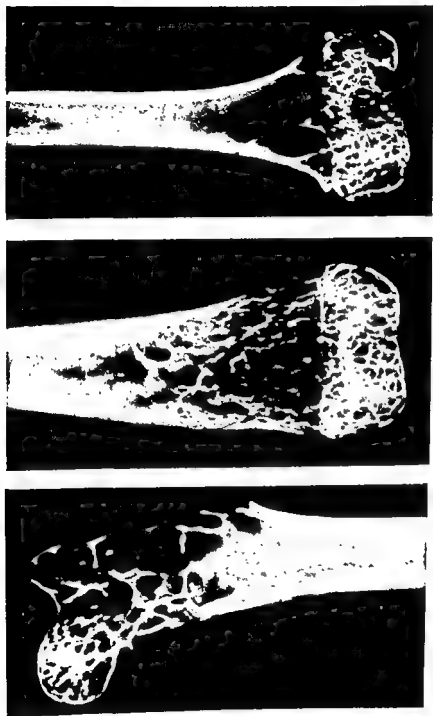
Frontal radiographs of proximal end of femur of mature male *S. cinereus* (left) and distal ends of femur of mature (center) and immature (right) males. Contact prints of higher magnification negatives of the radiographs represented by first and third images in figure 1. $\times 26$.
